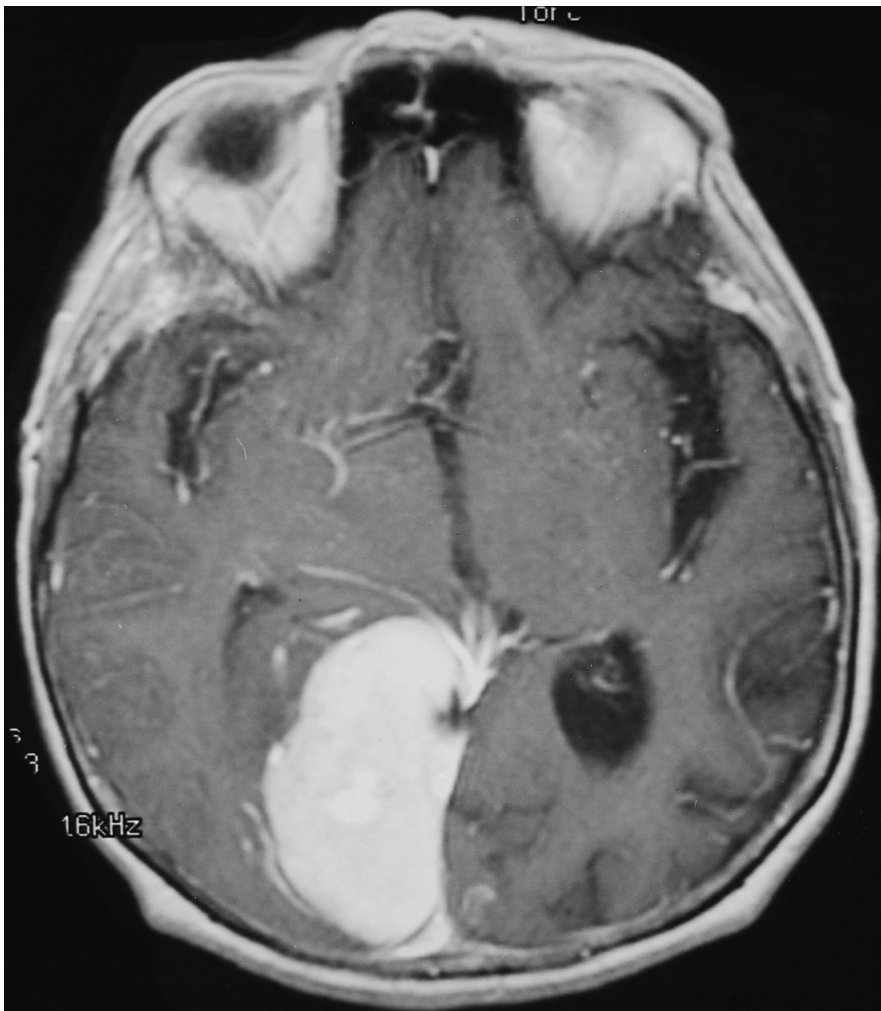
Enhanced T_1 -weighted axial magnetic resonance image showing large right occipital falcine meningioma with mass effect on brain.
